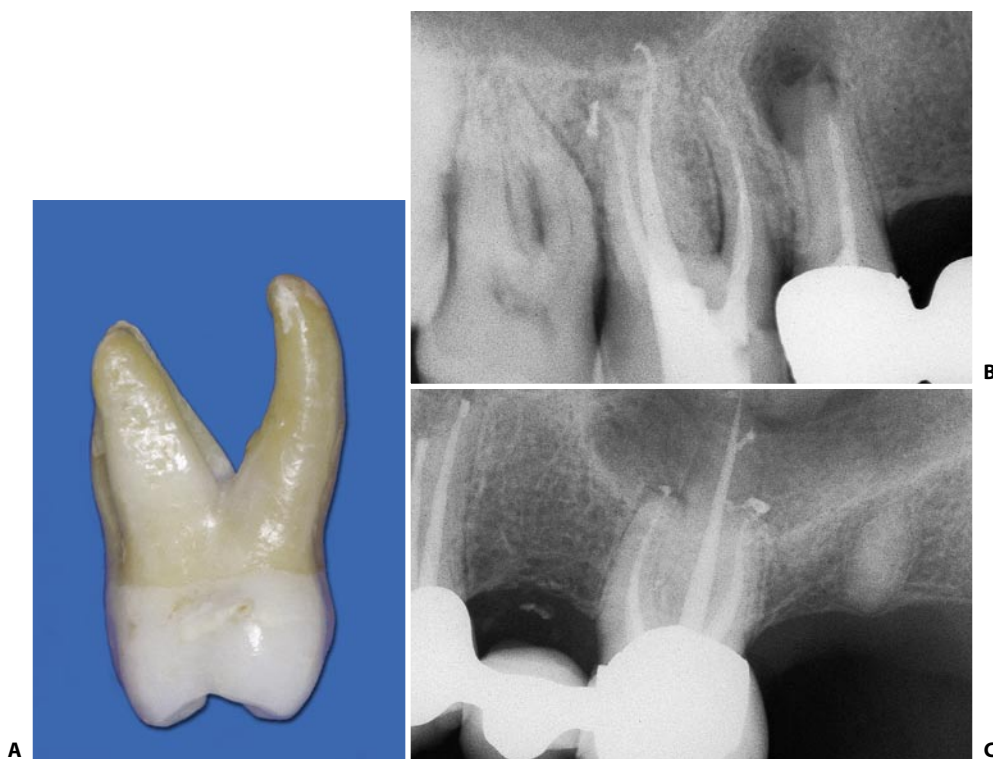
A. Photograph of an upper right first molar, seen mesially. Note the curvature of the palatal root, which faces buccally. B. Postoperative radiograph of the upper right first molar. Note the sinuosity of the palatal canal. C. The palatal canal of this upper molar has a large lateral canal directed distally.
